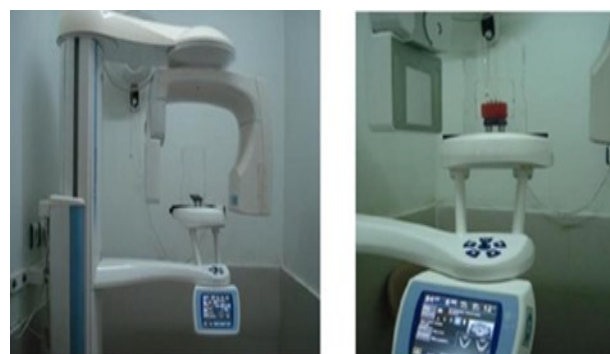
The Samples placed on NewTom CBCT
